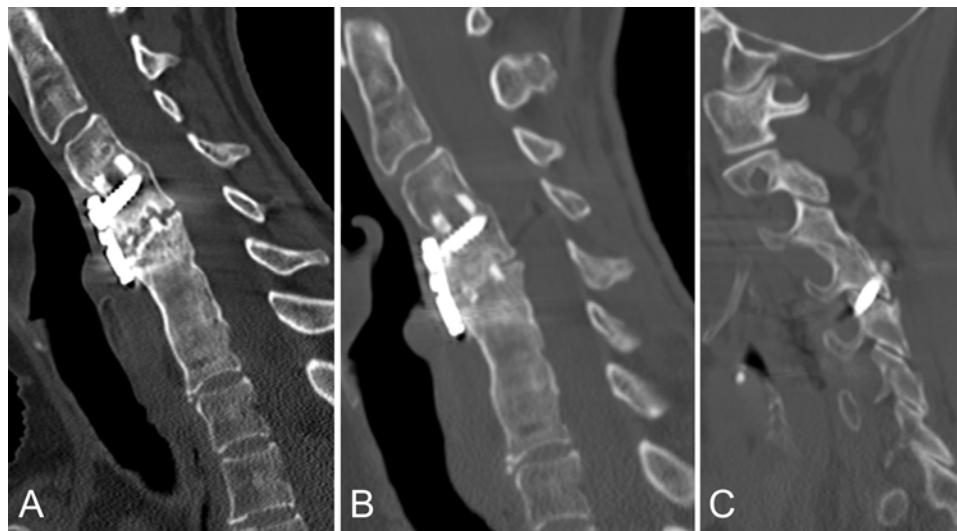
A: Sagittal CT scan of the cervical spine showing status after a C4–5 ACDF with persistent lucency through the C4–5 level and endplate irregularity consistent with nonunion at C4–5. There is evidence of previous osseous fusion at the C3–4, C5–6, and C6–7 levels. B and C: Sagittal CT scans obtained about 1 year after posterior fusion with transarticular facet screws, demonstrating incorporation and bridging of bone across the C4–5 discectomy and graft.
